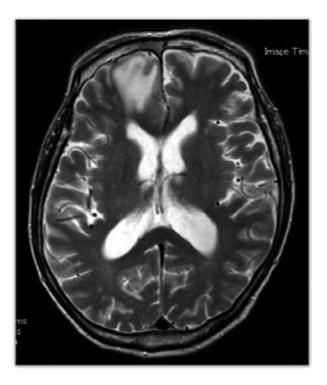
MRI (T2WI) after conscious lost in ER. Right frontal lobe abscess is depicted.
